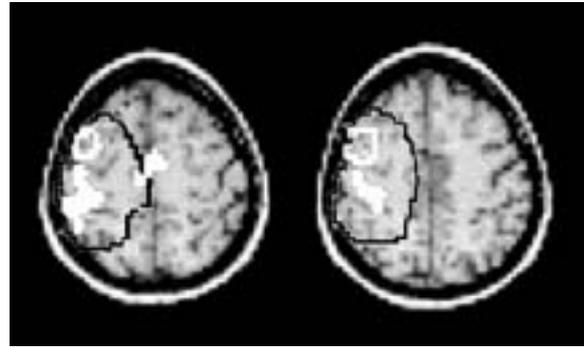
Coregistration of the perfusion abnormalities, the manifest lesion and cerebral activations after recovery in a patient with right-hemispheric infarction in the middle cerebral artery territory. Shown are two adjacent axial slices at the level of the cortical hand/arm representation. The DWI-lesion is outlined in white, the large area of impaired perfusion is outlined in black. The activation areas related to finger movement of the recovered hand adjacent to the DWI-lesion and in the midline corresponding to the supplementary motor area (white).
